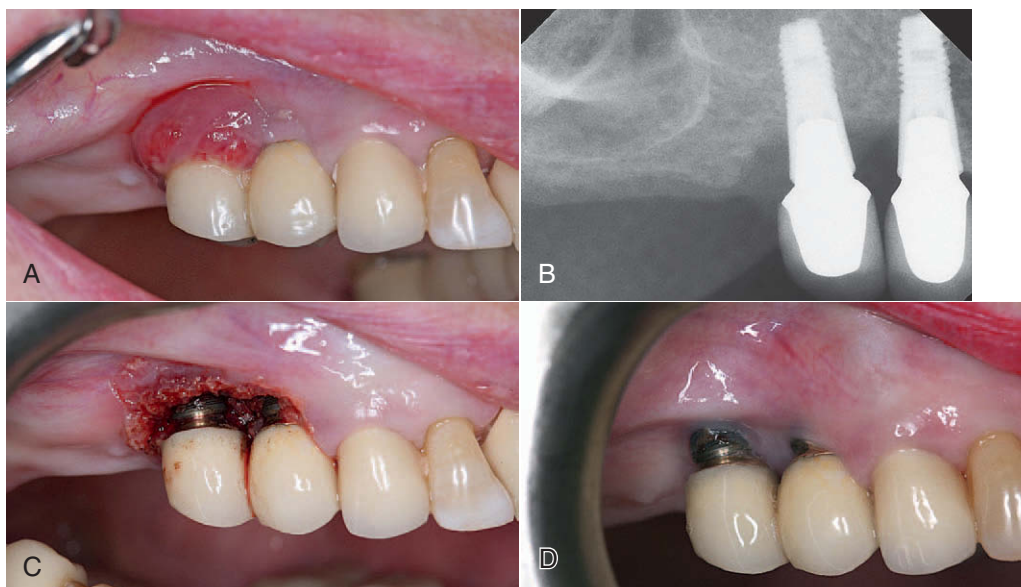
• A, Periimplantitis affecting implant in upper-right second premolar space. B, Radiograph of bone loss. C, Area after closed ultraspeed CO₂ laser debridement of periimplant tissue. D, Beautiful tissue response to laser and healthy periimplant tissue.
